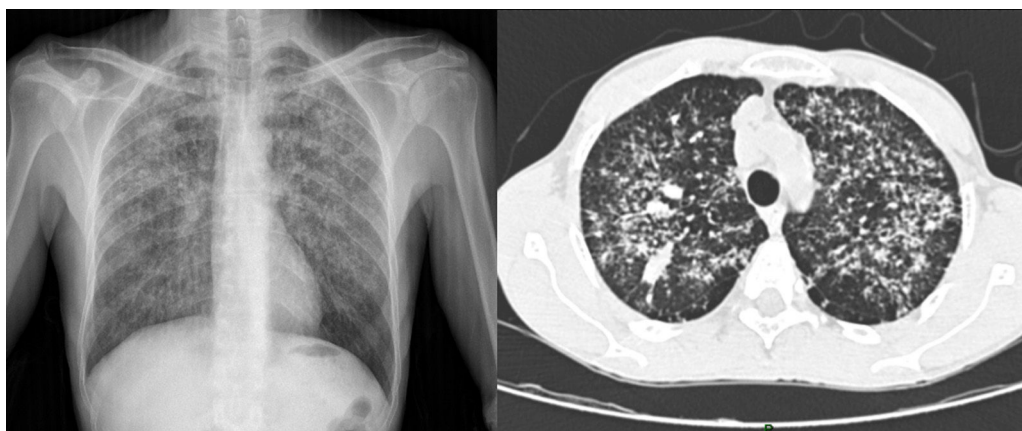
Chest X-ray and high-resolution computed tomography showing widespread bilateral reticulonodular opacities.
